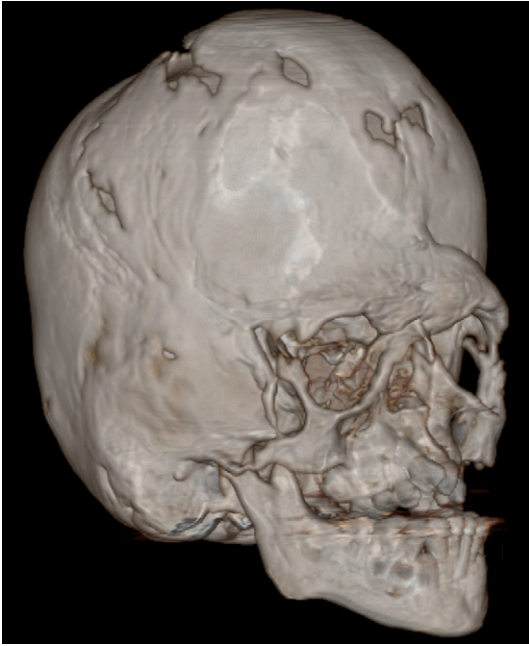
Pre-operative 3D CT scan of 10-year-old patient with Apert syndrome in which a Le Fort III distraction with internal and external devices was planned.
